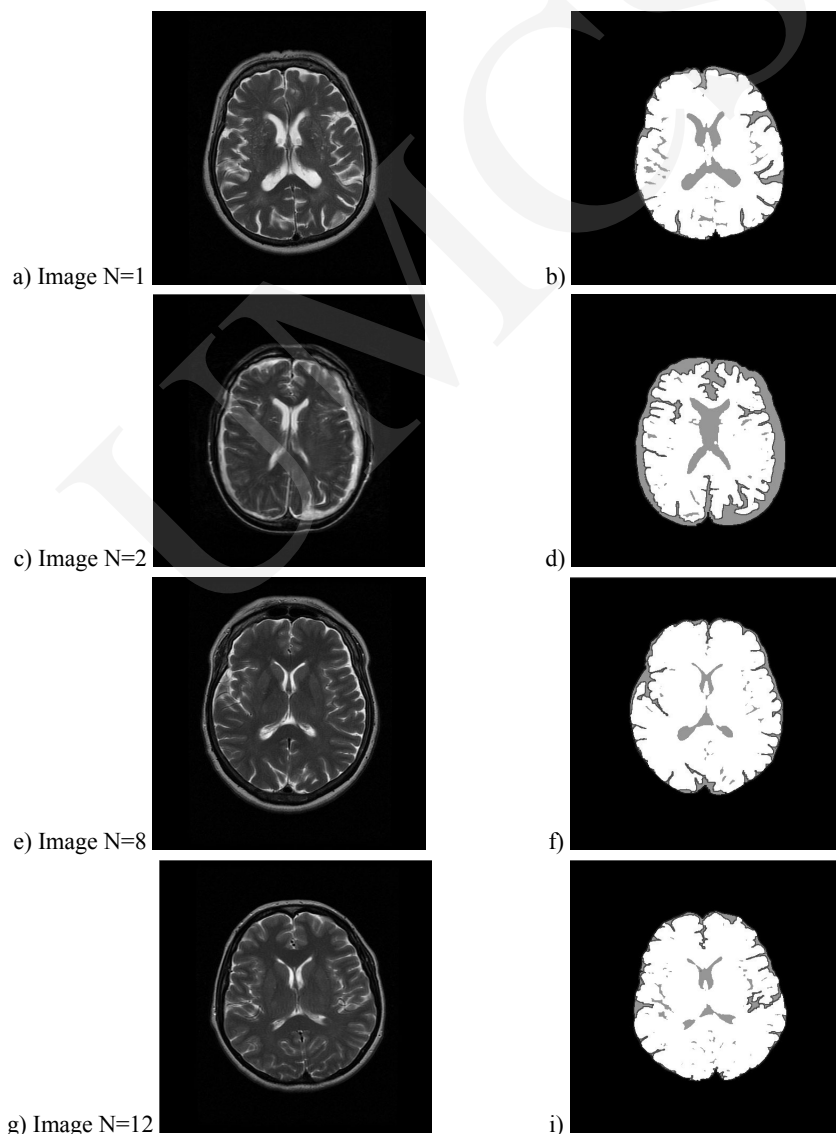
(a, c, e, g) the original brain MR image (b, d, f, i) contours of the forebrain and of the white brain matter
